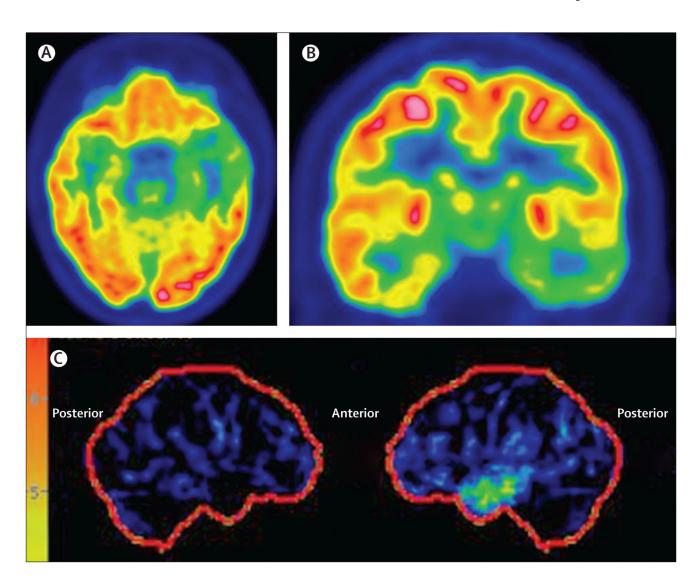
$^{18}$ F-fluorodeoxyglucose PET imaging for the localisation of epileptogenic brain regions in MRI-negative focal epilepsy
